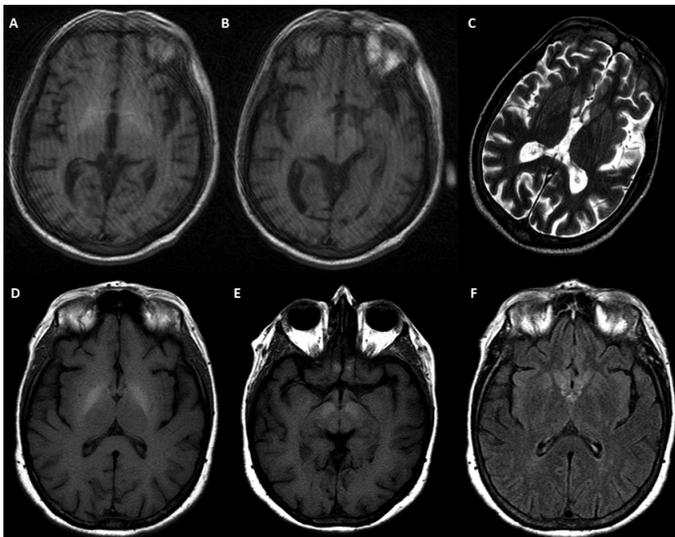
Brain MRI. Case 1: Axial T1-weighted images showing hyperintensities in GP(A) and mesencephalon(B); Axial T2-weighted image showing mild bilateral hyperintensities in striatum and global CSF space enlargement(C). Case 2: Axial T1-weighted images revealing symmetric hyperintensities in the GP(D) and substantia nigra(E); Axial T2-FLAIR image showing slight increase in the striatum signal(F).
